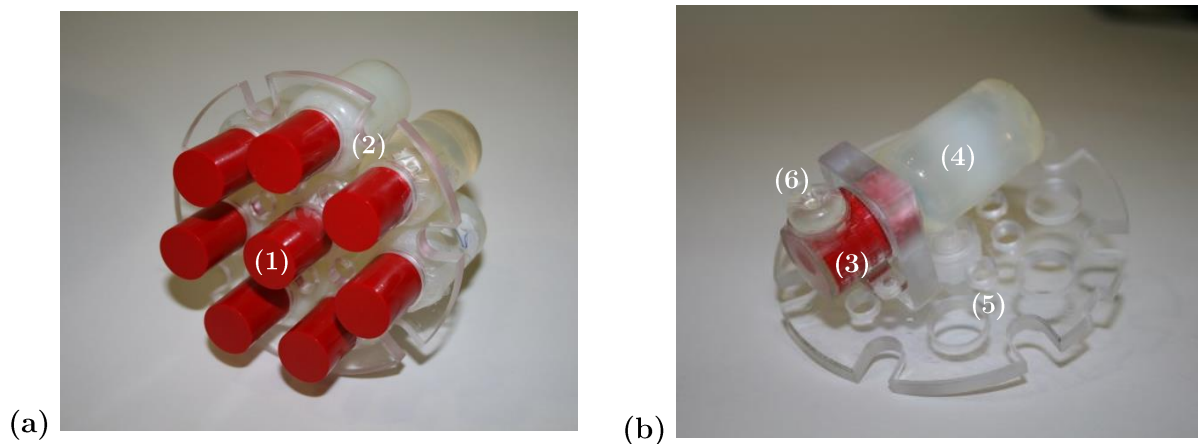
(a) Eight calibration flasks (1) were equally distributed using a dedicated PMMA holder (2). (b) The mounting (3) of the *gel tumor* (4) is attached to an adapter plate (5) and the metal fiducial is replaced with high accuracy ($<1 \text{ mm}$) by an MRI-visible marker (6) using a special template.
